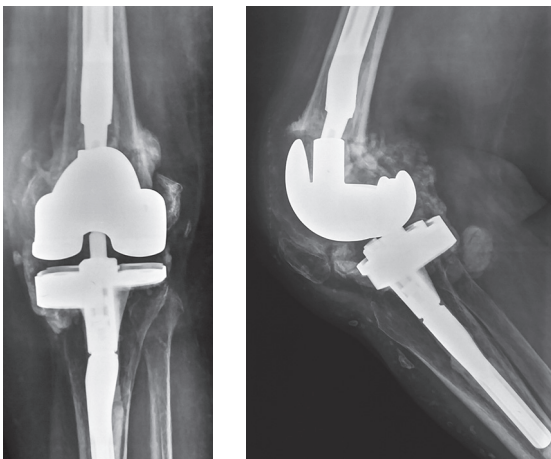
The knee X-rays of the female patient. The left femur pseudoarthrosis, the endoprosthesis components instability, separation of the intramedullary stem from the femoral component.
